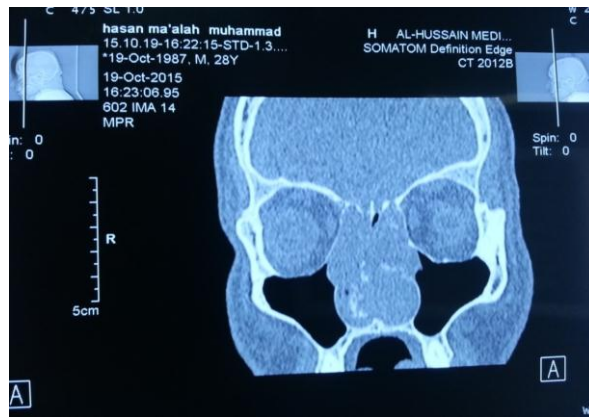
CT scan of a patient showing extensive involvement of nasal bony septum by cavernous haemangioma.
